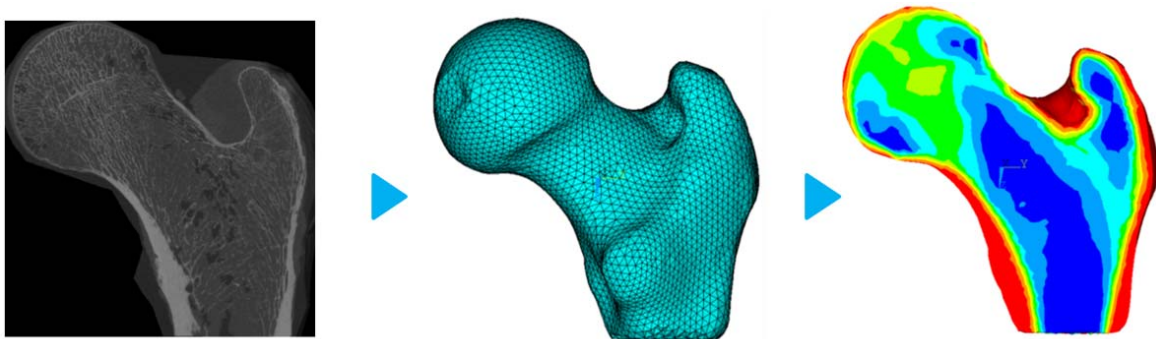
Continuum-level FE model of a human proximal femur generated from CT images.
